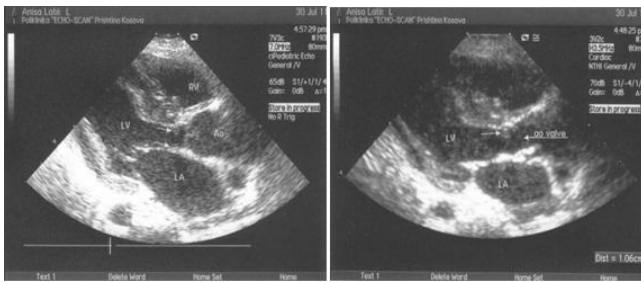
Transthoracic long-axis view in diastole (Fig 1a), and in systole (Fig 1b) shows subaortic shelf, and as a consequence, hypertrophy of the left ventricle and dilated ascending aorta
